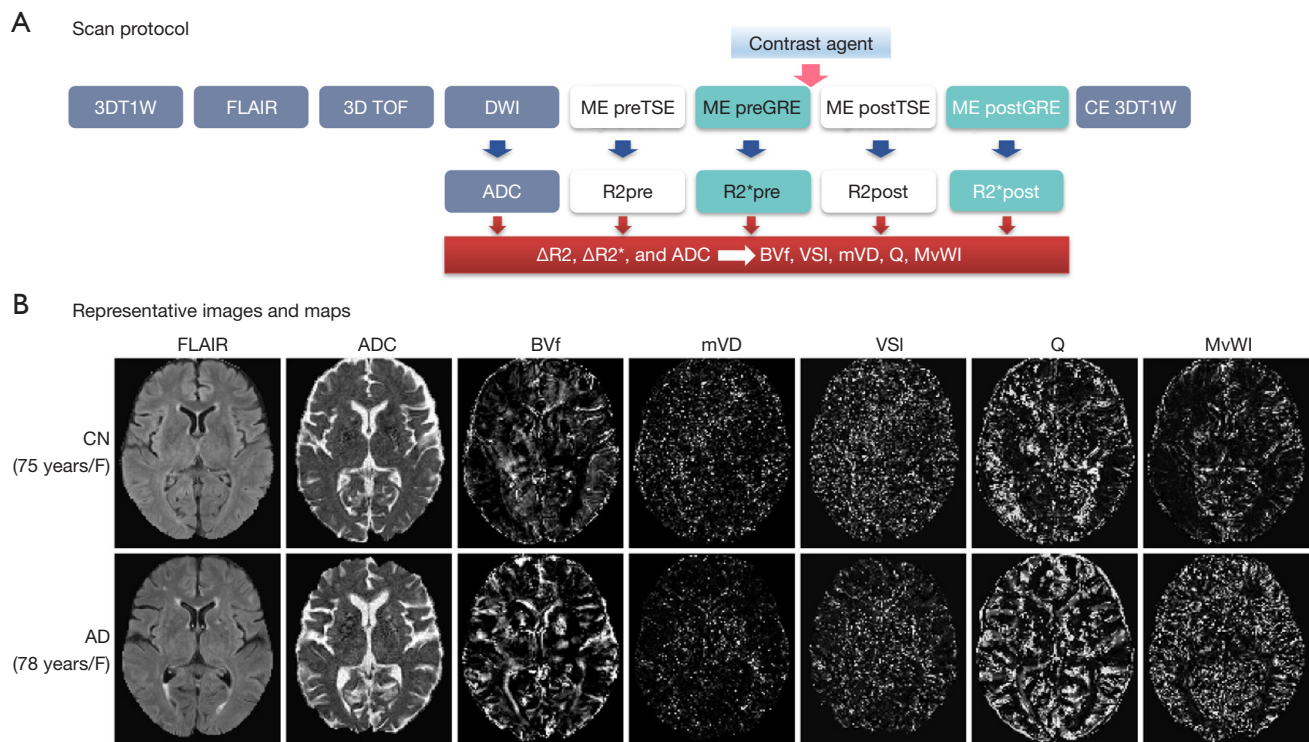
Scan protocol and representative images and maps. (A) Scan protocol with imaging acquisition sequences. R2 and R2* and ADC maps were calculated to map BVf, VSI, mVD, mean vessel density (Q), and MvWI. 3DT1W, 3D T1-weighted imaging; FLAIR, fluid attenuation inversion recovery to obtain white matter lesion volume; 3D TOF, 3D Time-of-flight MR angiography to evaluate any large vessel integrity; DWI, DWI to calculate ADC; ME preSE, ME SE imaging before injection of contrast agent to map preR2 (relaxation rate); ME preGE, multi-echo GE imaging before injection of contrast agent to map preR2*; pre, imaging before injection of contrast agent; post, imaging after injection of contrast agent; CE using Gd-based contrast agent (Gadovist, Bayer Schering Pharma AG, Berlin, Germany). (B) Representative images and maps of the microvascular indices obtained from one CN participant (75-year-old female) and one AD patient (78-year-old female). The window level for each representative map was the same for both the CN and AD participant. ADC, apparent diffusion coefficient; BVf, blood volume fraction; VSI, vessel size index; mVD, mean vessel diameter; MvWI, microvessel-weighted imaging; DWI, diffusion-weighted imaging; ME, multi-echo; SE, spin-echo; GE, gradient-echo; CE, contrast enhancement; Gd, Gadolinium; CN, cognitively normal; AD, Alzheimer's disease.
